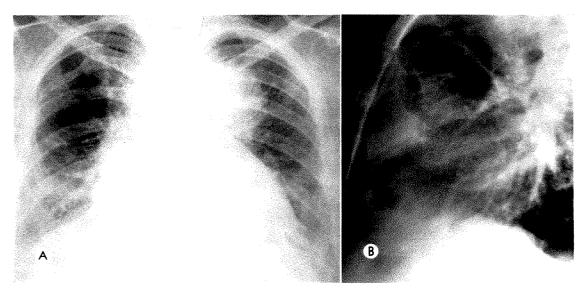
Case 1. (A) Frontal teleroentgenogram of the chest showing enlarged mediastinal and hilar masses (especially on the left side) and enlargement of the cardiac silhouette. The deformed fourth posterior right rib is due to exploratory thoracotomy made 7 years earlier. (B) Lateral roentgenogram of the chest showing filling of the entire retrosternal space.
